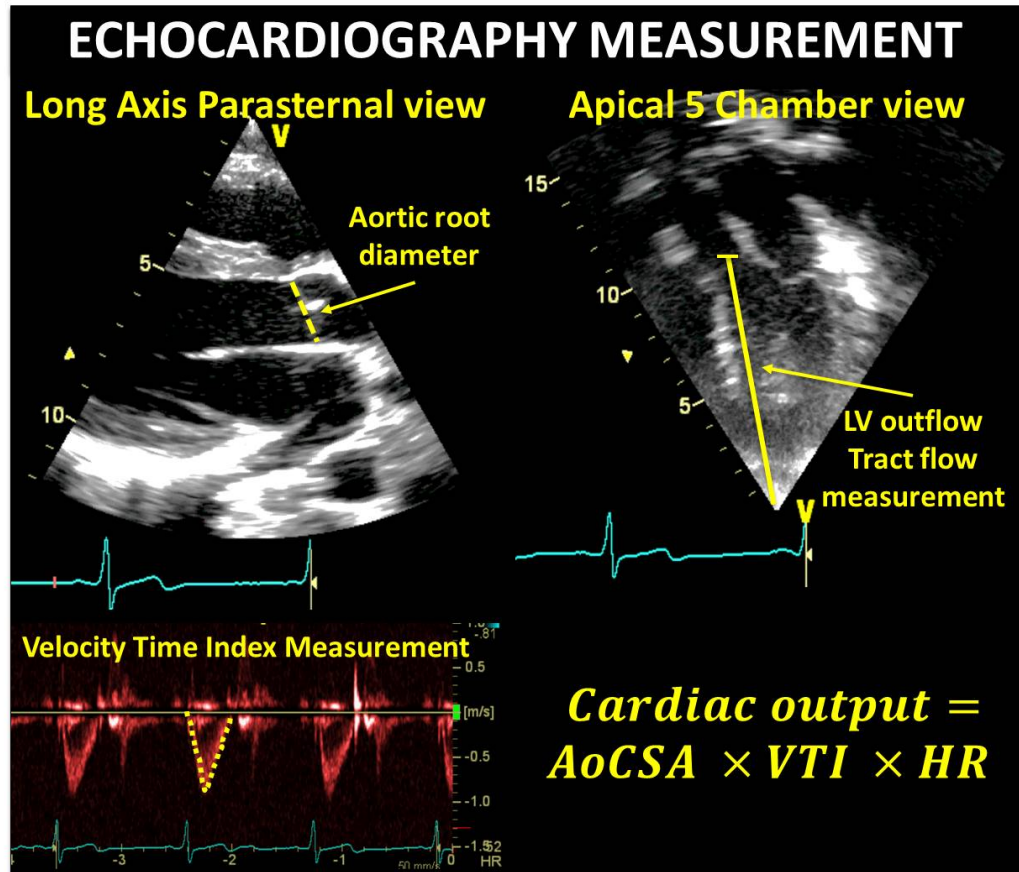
Echocardiographic measurement of cardiac output and stroke volume.
